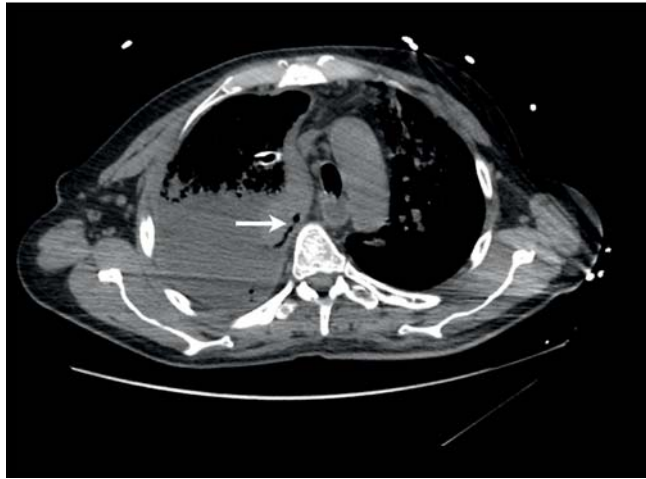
Computed tomography scan image of massive right pleural corpus-colateral effusion. A small esophago-pleural fistula could be identified (arrow).
